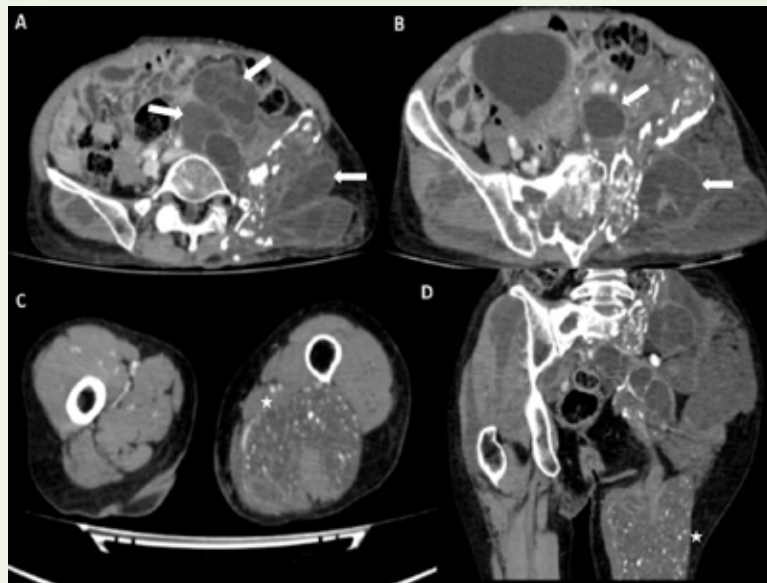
Case of a 60-year-old female with pain in the left lumbar and iliac region: Contrast-enhanced computed tomography axial sections (Image A and B) of the abdomen reveal multiple multi-loculated peripherally enhancing lesions at various stages (marked by white block arrows) noted in bilateral gluteus maximus, left gluteus medius and minimus, left piriformis and iliacus muscle and left obturator externus. Image C is an axial section of contrast-enhanced CT at the level of the proximal femur and Image D is a coronal MPR reconstruction of contrast-enhanced CT at the level of the pelvis and upper thigh of the same patient showing multiloculated cystic lesions with few septations and multiple tiny punctate foci of calcification (marked by white stars) in the left adductor and hamstring muscles.
